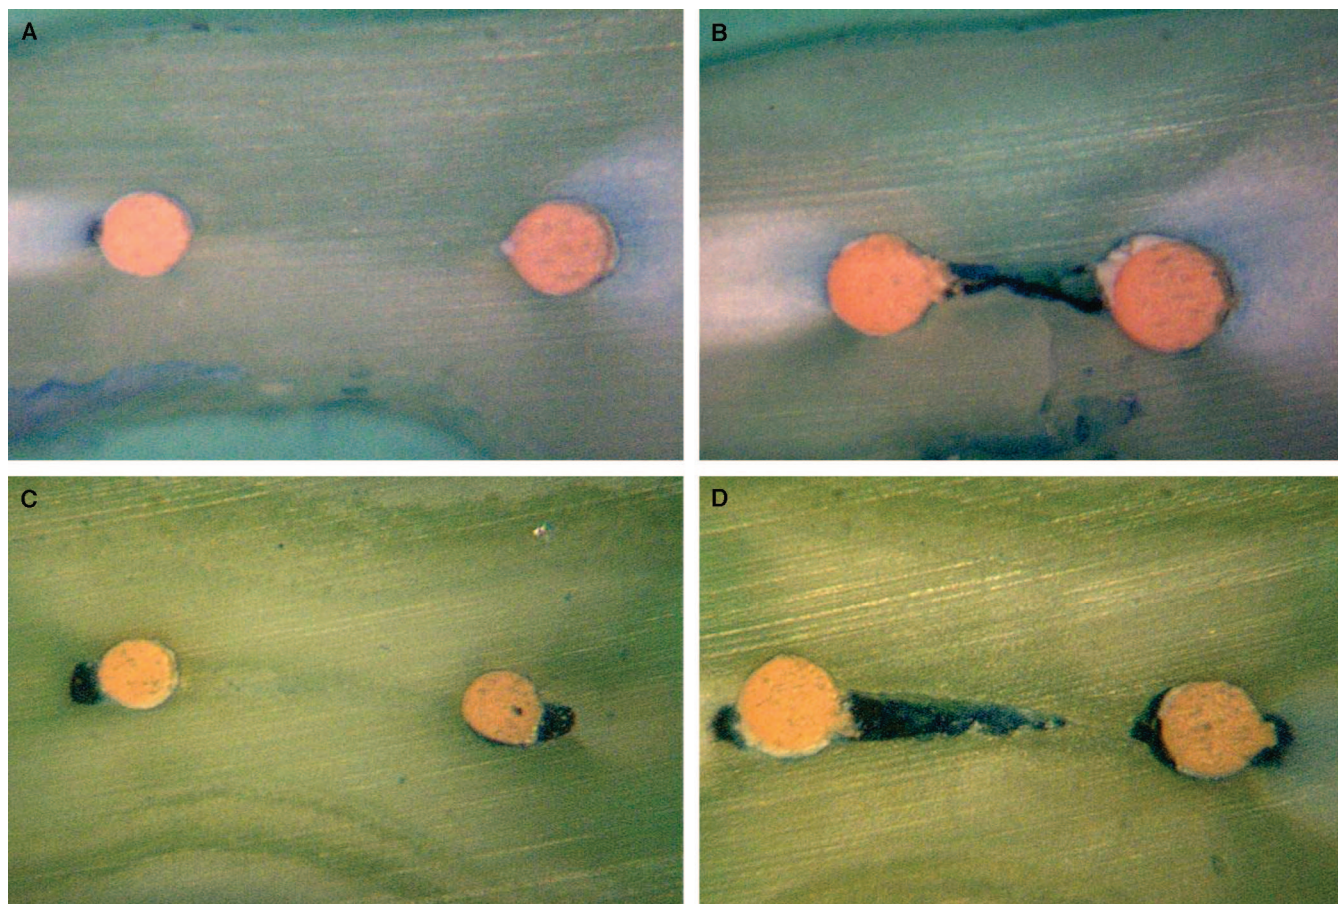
In the MB root of maxillary first molar, type B was shown at the 2 mm level (A), but type C2 (complete isthmus) was found at the 4 mm level in the same root (B). Type B canal configuration was shown at the apical 2 mm level of the mesial root of mandibular first molar (C), but the configuration at the 4 mm level was like type C1 (partial isthmus) in the same root (D). Original magnification: 100 \times .
